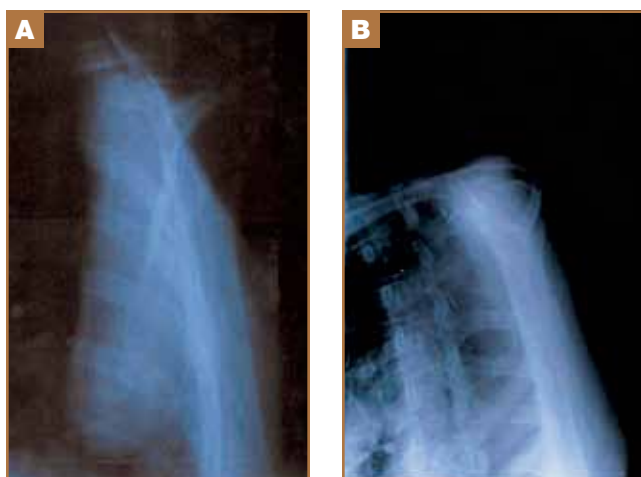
Pre-reduction scapular “Y” radiograph demonstrating the inferior angle of the scapula in an intrathoracic location (A). Post-reduction radiograph demonstrating successful reduction of the scapula to an extrathoracic position (B).
